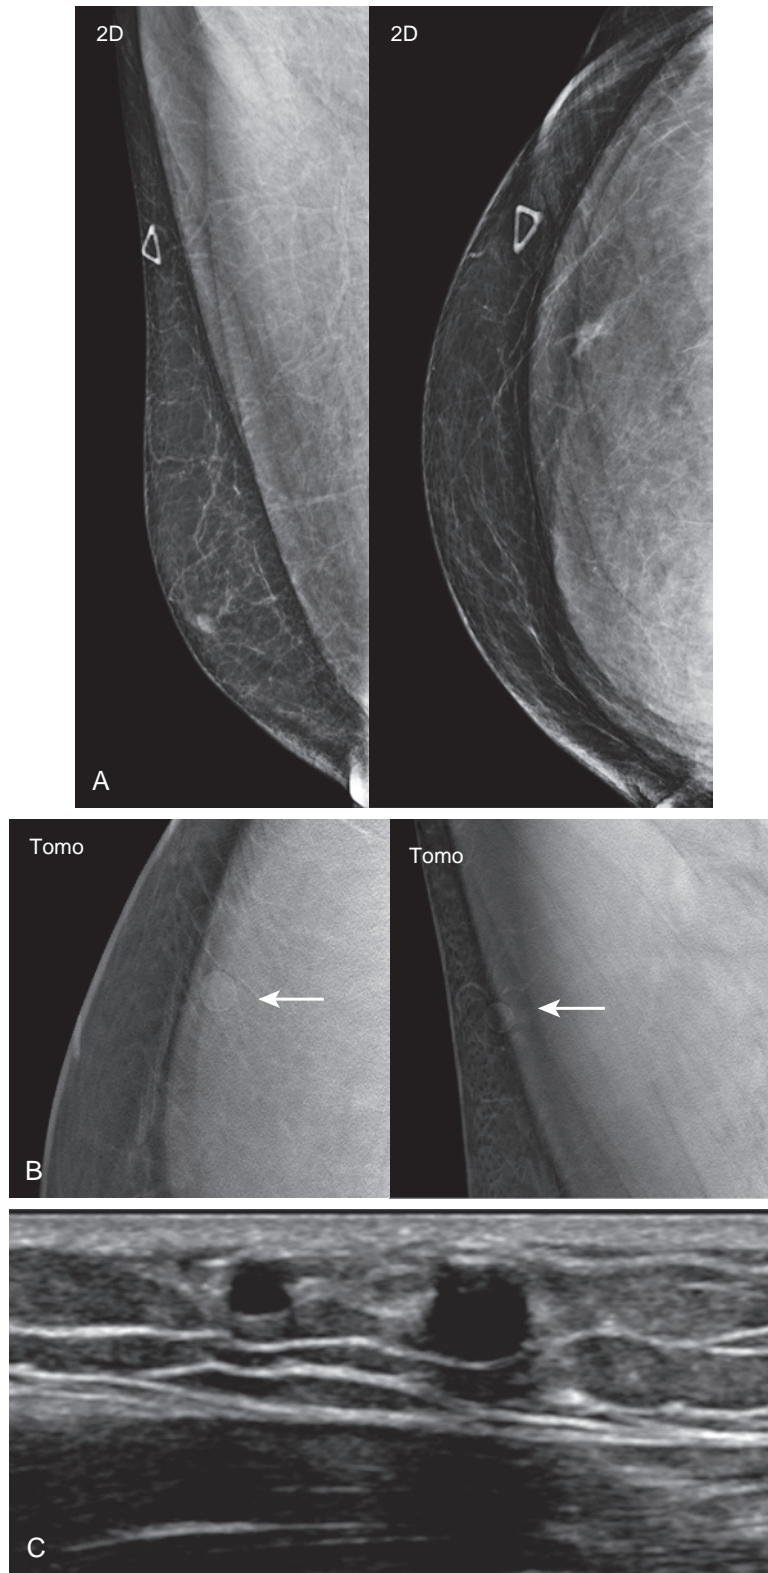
Oil cysts. A 49-year-old man presents with a small palpable area in the right breast. (A) 2D mammography did not show a focal abnormality. (B) Tomosynthesis slice views demonstrate two round, fat-density masses (*arrows*). (C) Targeted ultrasound demonstrates two small cysts consistent with oil cysts.
